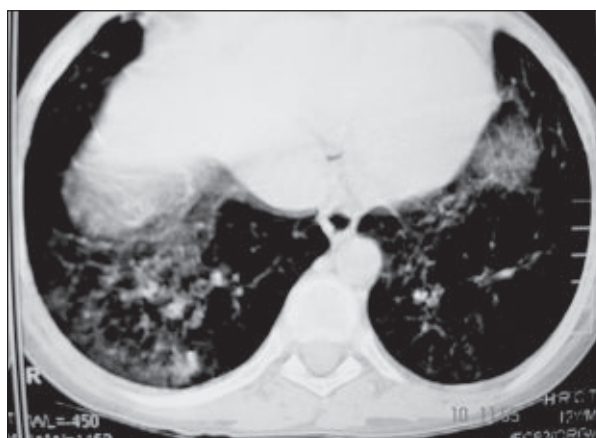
HRCT of chest showing reticulonodular and ground glass opacities in posterior basal region (both lungs).
